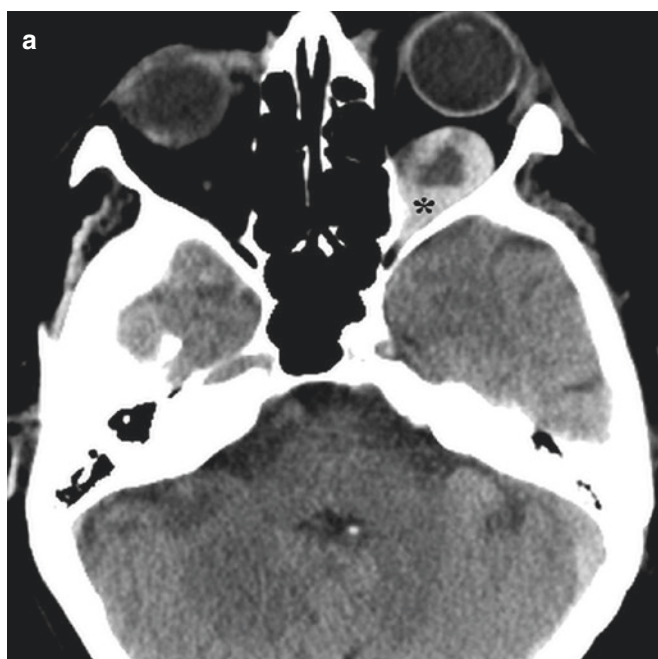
Thrombosed orbital varix. A 79-year-old with sudden onset of diplopia and proptosis. (a) NCCT demonstrates an intraconal left orbital mass causing deviation of optic nerve. The mass has peripheral hyperdensity with attenuation measuring 70–80 Hounsfield unit consistent with acute thrombus. Note a hematocrit level within the mass. (b) The axial T2 MRI shows hypointensity along the periphery of the lesion consistent with thrombus, and a hematocrit level, confirming the CT
